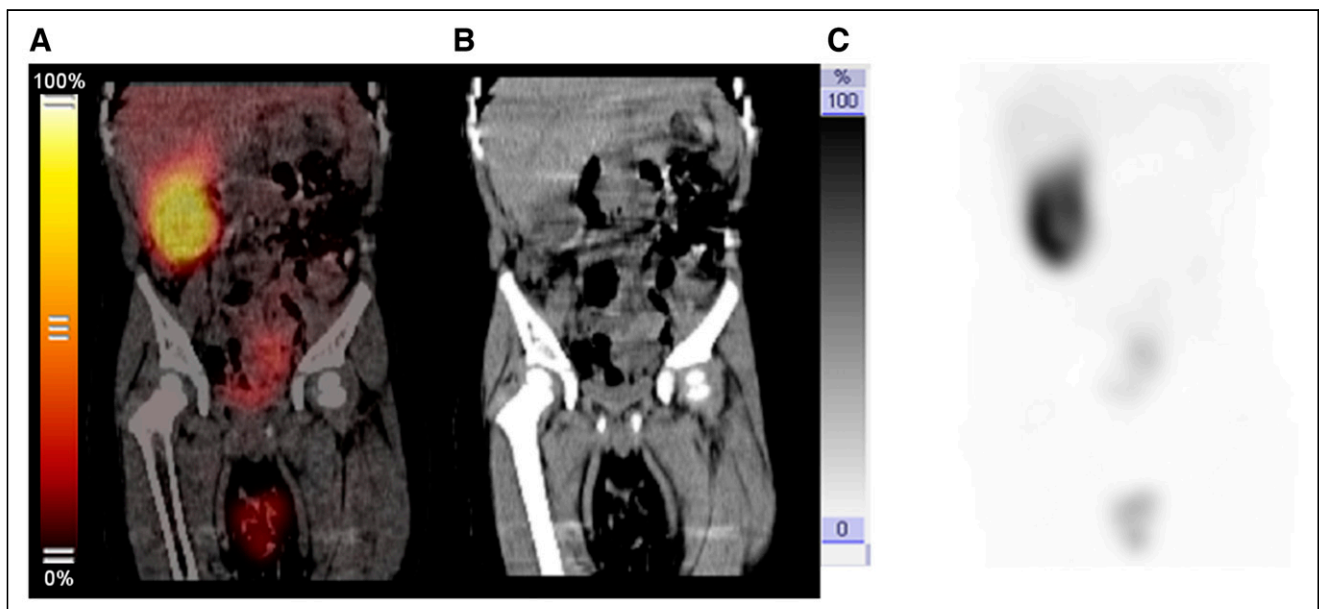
(A) Fused sagittal image of ^{99m}Tc -DMSA study of child with history of cross-fused ectopic kidney, showing high background, liver, and colon uptake. (B) Corresponding CT image. (C) Corresponding SPECT image.
